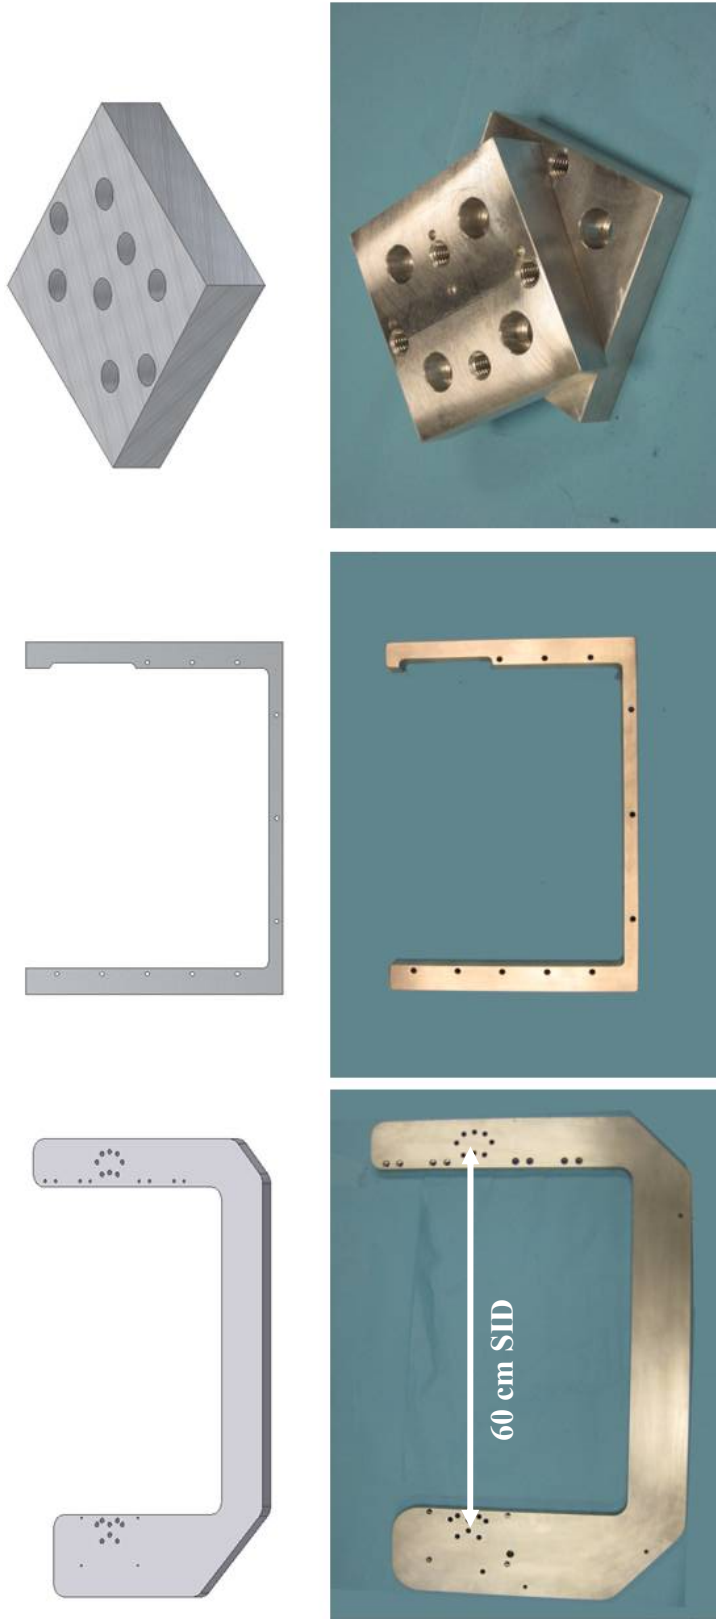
CAD images of the (top left) modeled U-arm (top row, middle) U-shaped detector holder and (top row, right) 3.11° angled wedge for the source and detector to modify the relative tilt of the CT system. The equivalent photographs of the manufactured aluminum pieces are shown in the bottom row.
